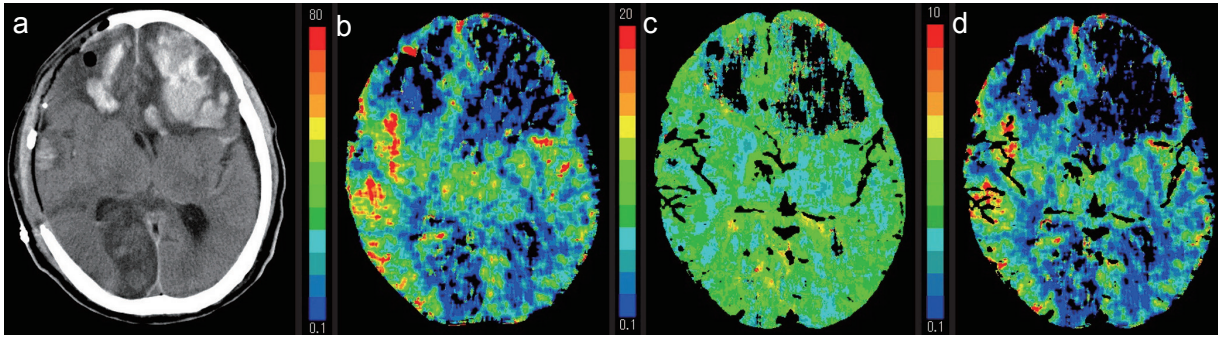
Computed tomography scan (a), cerebral blood flow map (b), mean transit time map (c), and cerebral blood volume map (d).
